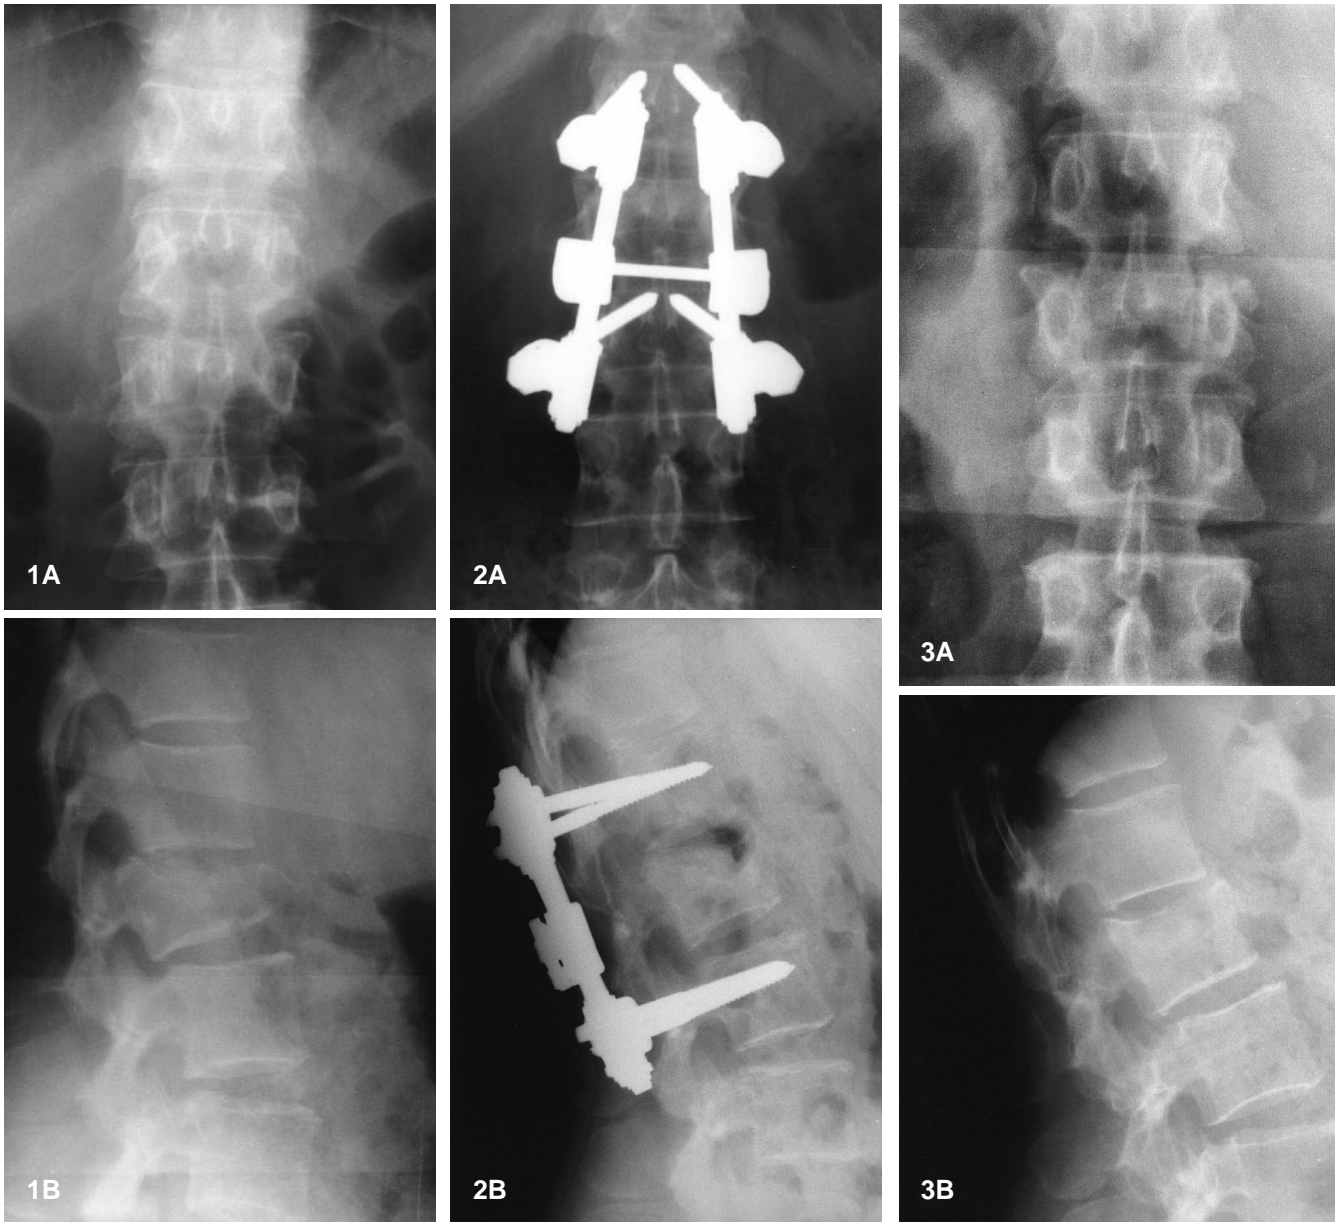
A Anteroposterior (AP) and B lateral radiographs of burst L2
